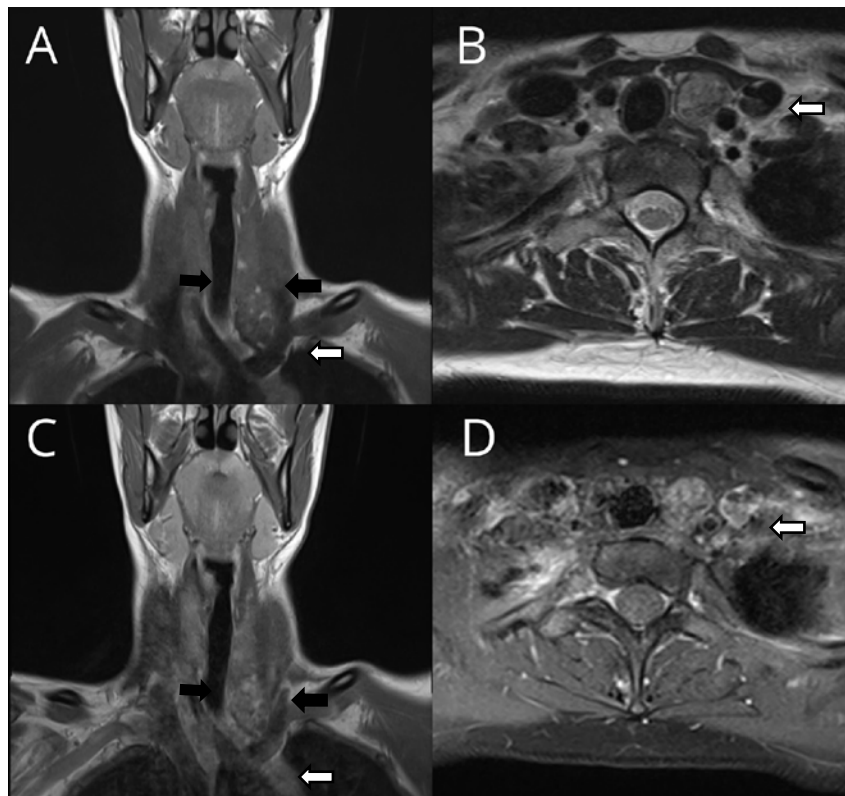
Magnetic resonance imaging (MRI) examination: T1 weighted image in the coronal plane (A) and T2 weighted image in the axial plane (B) showing a well-circumscribed paratracheal mediastinal soft tissue mass on the left (white arrows) with mild compressive effect on the trachea; T1 weighted image in the coronal plane (C) and T1 weighted image with fat saturation in the axial plane (D) after gadolinium contrast administration showing an inhomogeneous enhancement of the soft tissue mass (white arrows). Black arrows in A and C indicate normal right and left thyroid gland lobes.
